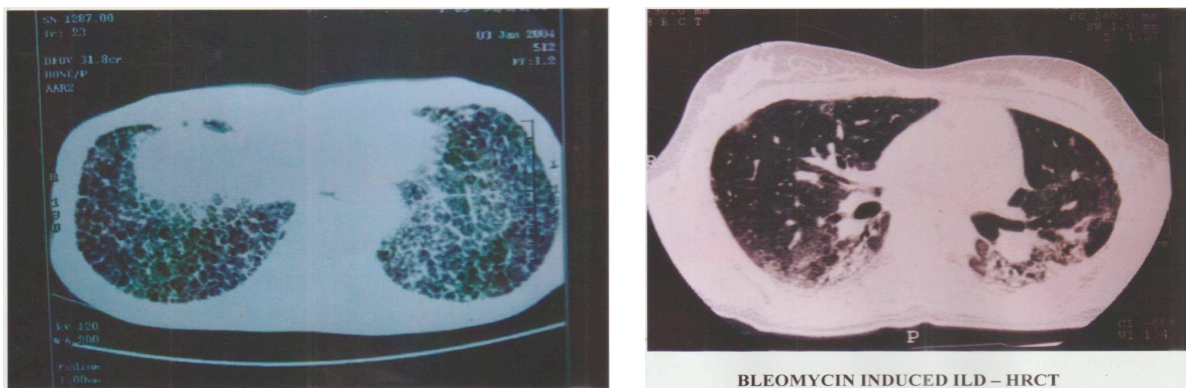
IPF - Honey Combing in HRCT
